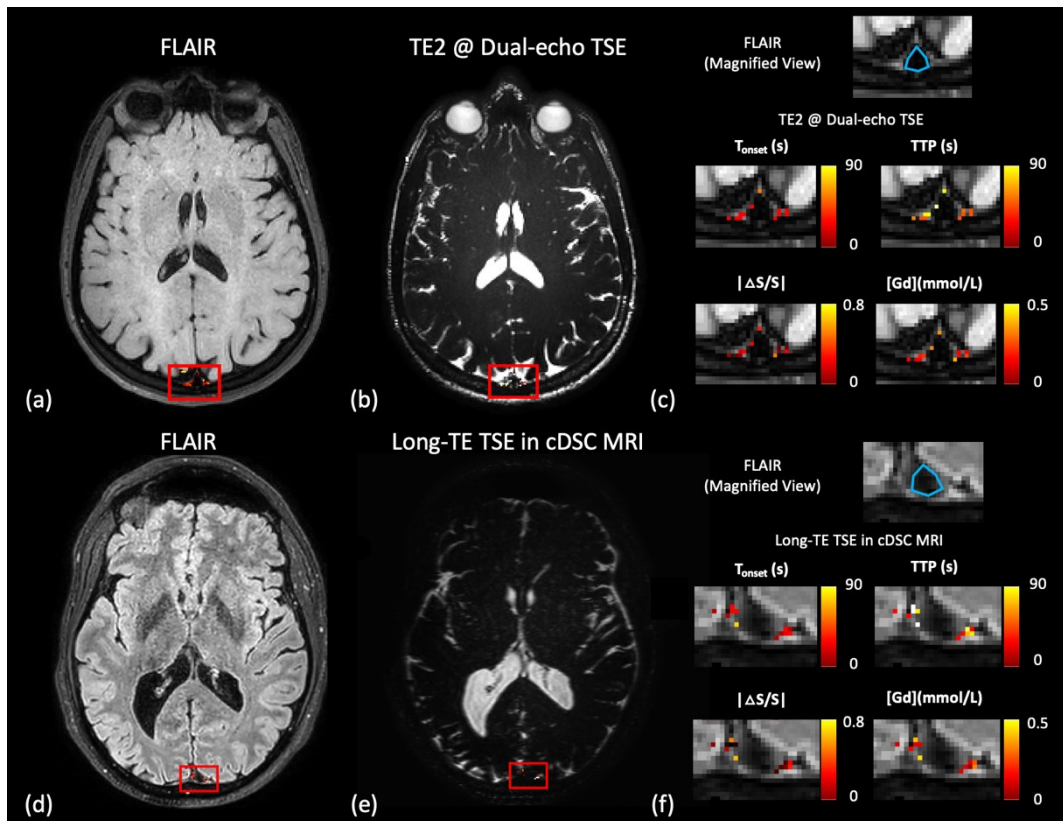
Dual-echo TSE and the long TE TSE images around the dural sinuses. Representative results for the measurement of dynamic signal changes in the CSF from human scans on 3T are shown. The region-of-interest (ROI, red boxes) around the dural sinuses (DS) (especially the superior sagittal sinus) that contains the meningeal lymphatic vessels is manually drawn. (a) The FLAIR image is
